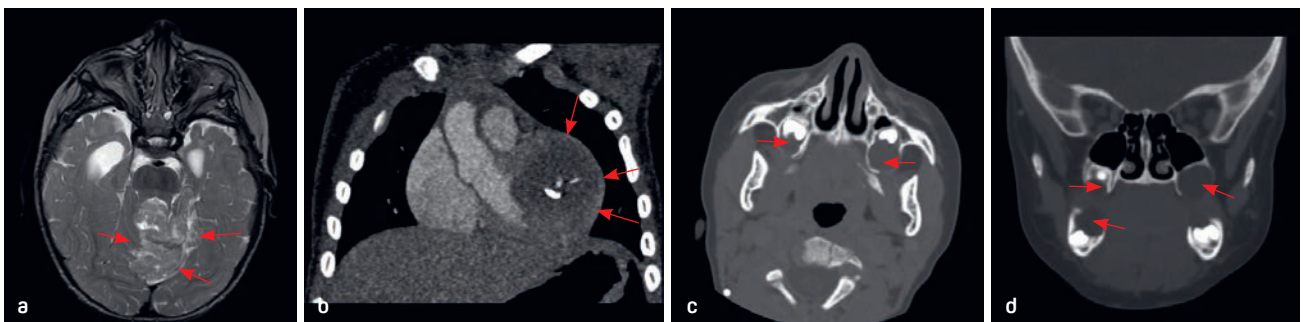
(a) At 1 year of age, this patient underwent resection and postoperative chemotherapy for a desmoplastic medulloblastoma. An axial MRI cut demonstrates the tumor (arrows). (b) Chest CT demonstrates a cardiac fibroma (arrows). (c and d) Axial and coronal CT cuts demonstrate expansile jaw cysts in the right and left maxilla and right mandible (arrows).
